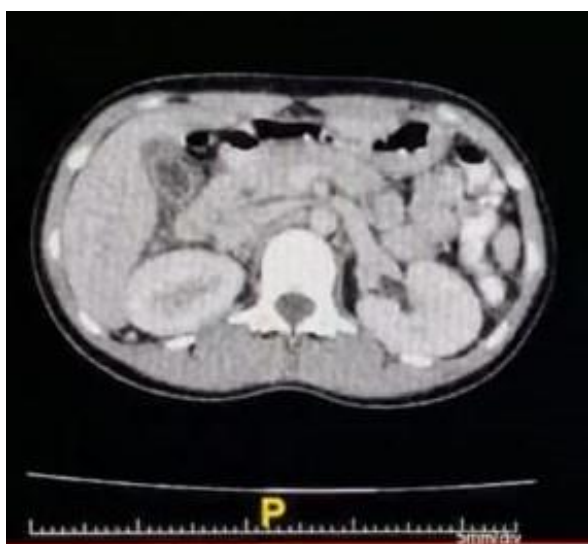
Abdominal CT demonstrated diffuse thickening of gallbladder wall (8 mm) and pericholecystic fluid without any calculus found (white arrow).
